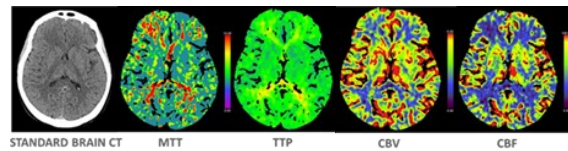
Basal CT (the first one from the left) and qualitatively-assessed brain pCT images (the last four) acquired during acute FHM aura symptoms. CT: Computed Tomography; MTT: Mean Transit Time; TTP: Time To Peak; CBV: Cerebral Blood Volume; CBF: Cerebral Blood Flow
